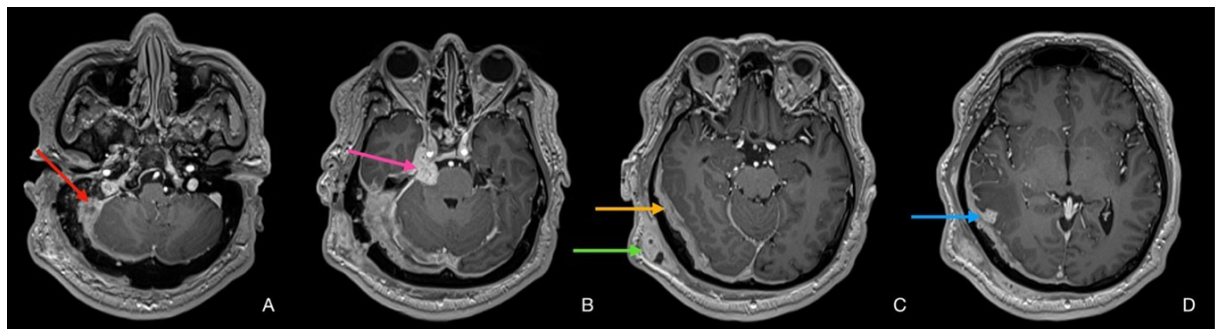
Axial T1-weighted gadolinium contrast-enhanced MRI sections. a) Section at ear canals showing enhancing inflammatory tissue extending from right periauricular soft tissue through abnormal modified right petrous temporal bone to posterior fossa (red arrow). b) Nodular deposit (pink arrow) extends into the right prepontine cistern, affecting right trigeminal nerve. c) Plaque-like enhancing dural thickening extending cranially to surround the right temporal lobe (orange arrow). Sub-galeal nodular enhancing soft tissue (green arrow) in the temporoparietal area. d) Temporal nodular dural focus with surrounding cerebral oedema and midline shift (blue arrow).
